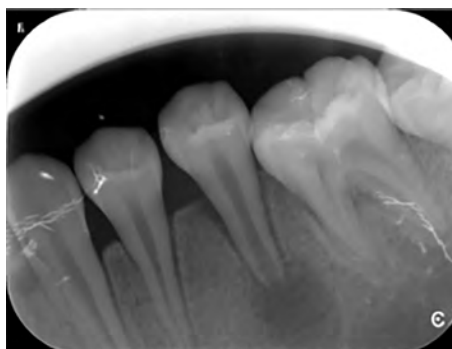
Large periapical radiolucency and widened PDL.
